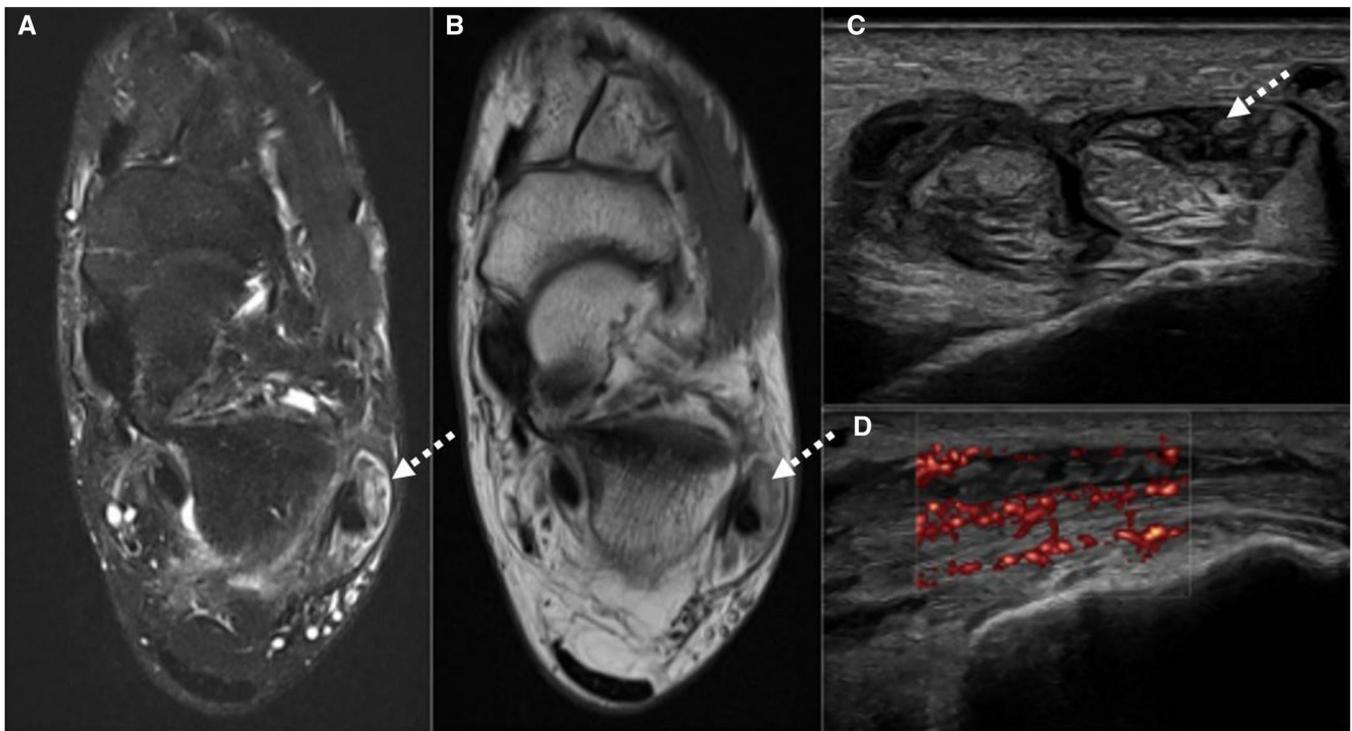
Axial MRI fat-suppressed proton density (A) and T1W (B) images of the ankle demonstrating low signal intensity calcium depositions (dashed arrows) within the peroneal tendon sheath with associated tenosynovitis. Corresponding ultrasound images in short axis (C) demonstrating echogenic material in peroneal tendon sheath (dashed arrow) and long axis image (D) shows neovascularity on power Doppler in keeping with tenosynovitis (D).
